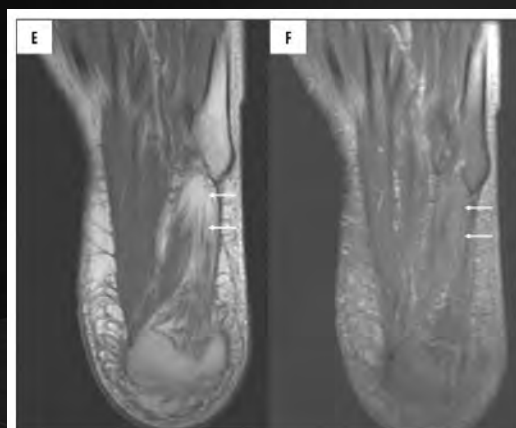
SE T1-weighted axial (E) and fat suppressed FSE T2-weighted axial (F) images of left foot show the atrophy of the abductor digiti minimi muscle (arrows) attached to the base of the 5th metatarsus.
